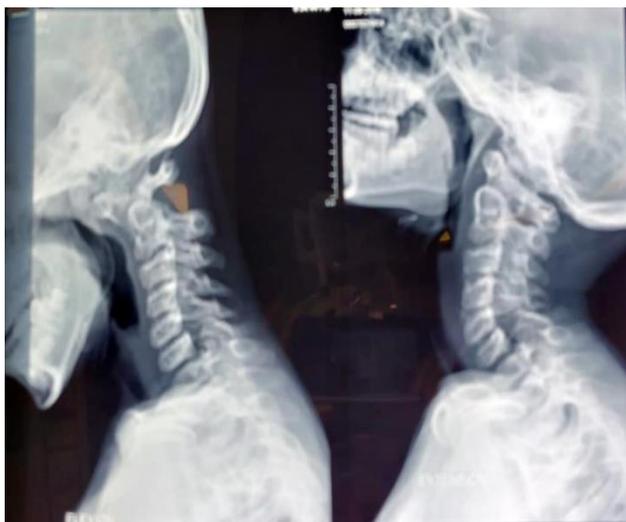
X-ray cervical spine lateral in flexion and in extension.
